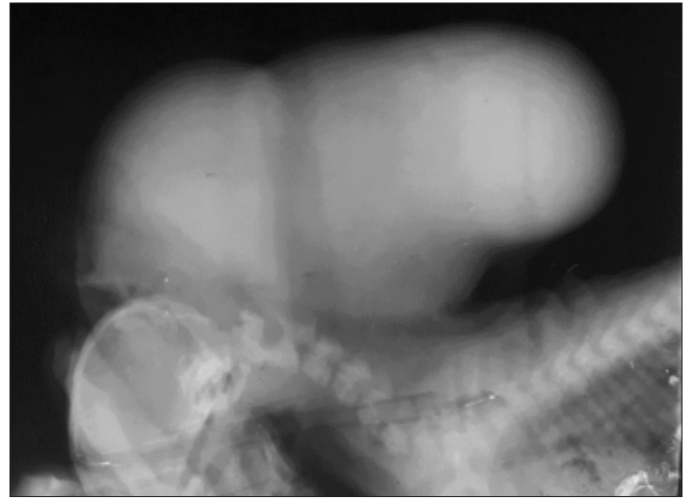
Radiograph showing soft tissue opacity of the mass.
